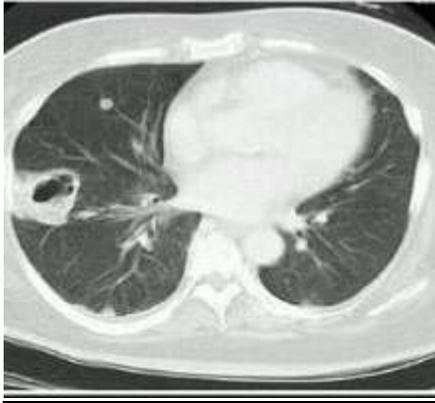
CT scan showing lung abscess
